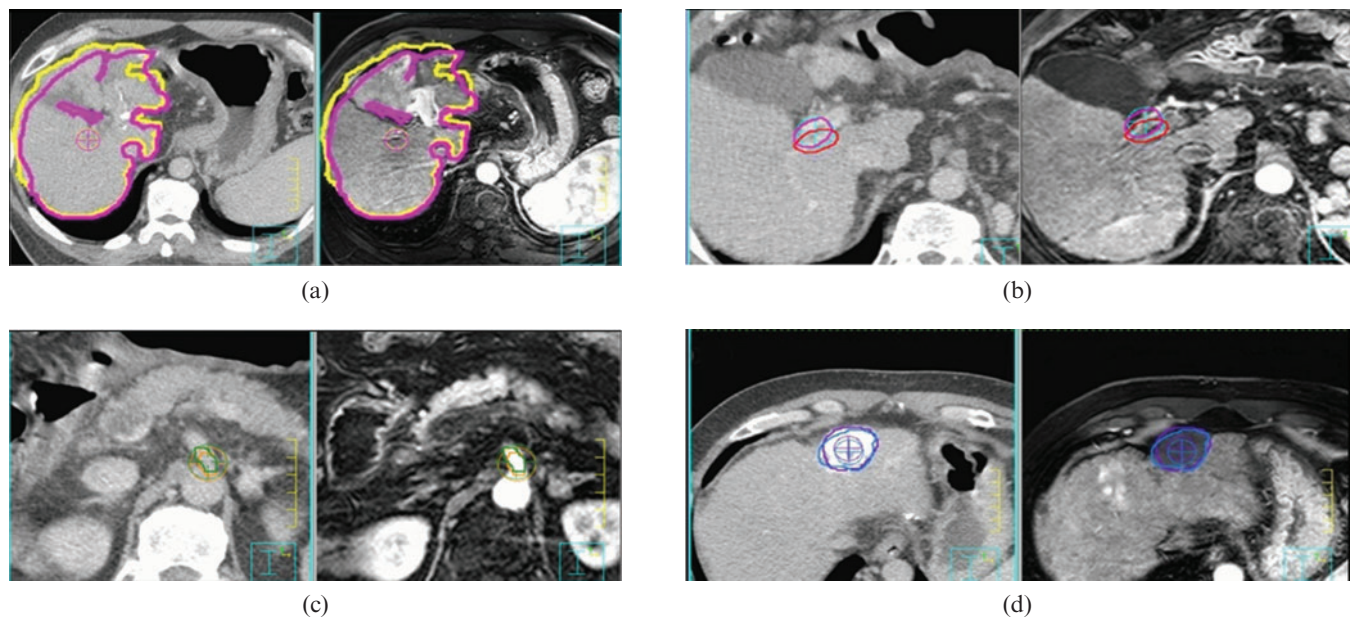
(a) Point chosen nearest the centre of the liver structure and (b–d) three anatomical landmarks were placed on CT and MRI fusion images. (b) Portal vein conjunction, (c) superior mesenteric artery bifurcation and (d) noticeable point.
